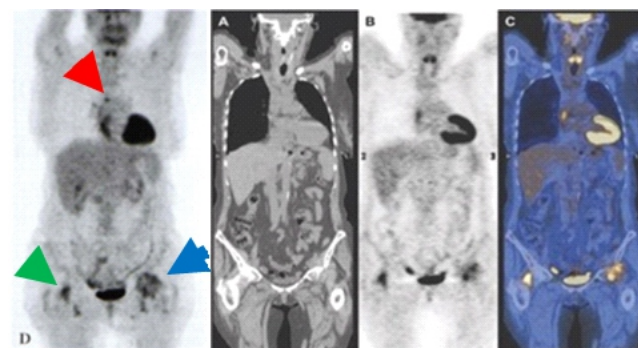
A 64 year old woman with Non Hodgkin Lymphoma diagnosis, immunosuppression after chemotherapy and joint pain at the left hip joint. body ^{18}F -FDG PET/CT shows: typical and expected lymphodal uptake (SUV max 6.1) due to NHL recurrence; typical and expected uptake at left hip joint (SUV max 6.4) raised the suspicion of a septic process; unexpected uptake in the right hip muscular insertions (SUV max 6.5).
